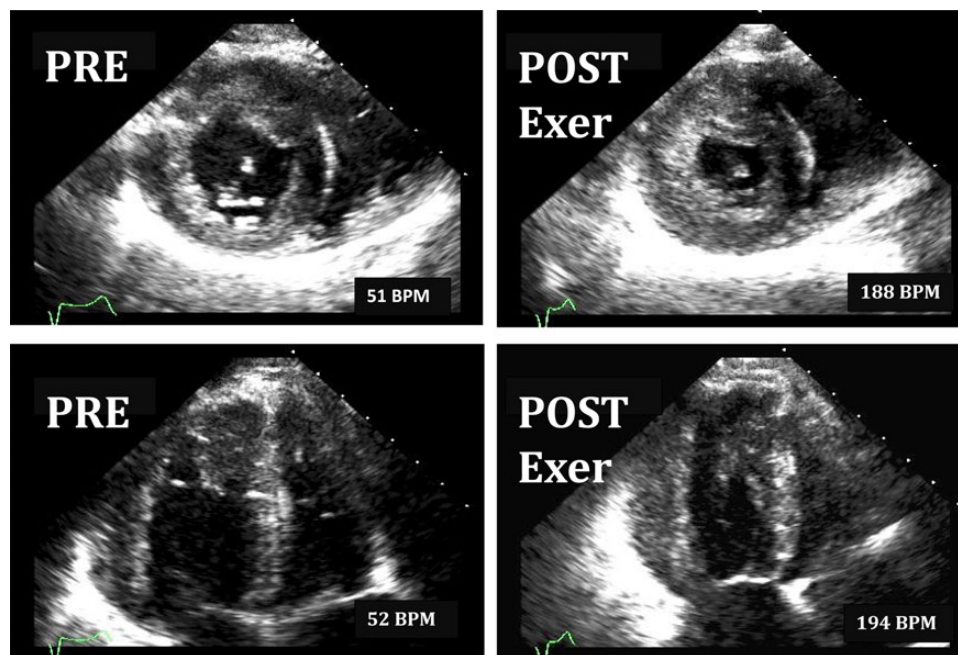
Exercise (Exer) SE in a patient with situs inversus and congenitally corrected transposition of the great arteries where the morphologic RV is the systemic ventricle. Resting and peak exercise image format are shown displaying end-systolic frames in the parasternal short axis and apical four-chamber views taken at rest (PRE) and peak exercise (POST). The desired response of increased global myocardial thickening and base-to-apex shortening with a significant decrease in right ventricular end-systolic volume is evident in the post-exercise images.
